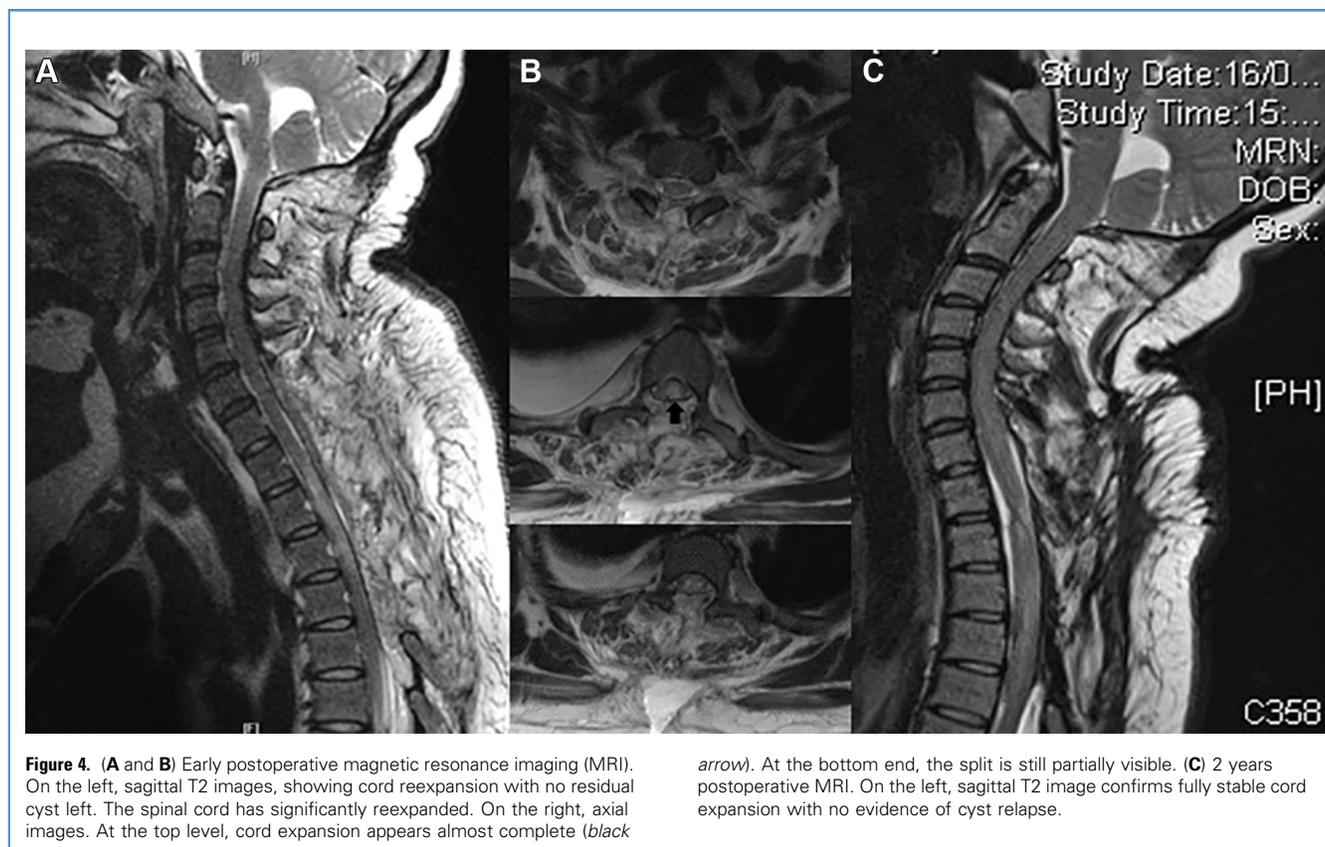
(A and B) Early postoperative magnetic resonance imaging (MRI). On the left, sagittal T2 images, showing cord reexpansion with no residual cyst left. The spinal cord has significantly reexpanded. On the right, axial images. At the top level, cord expansion appears almost complete (black
